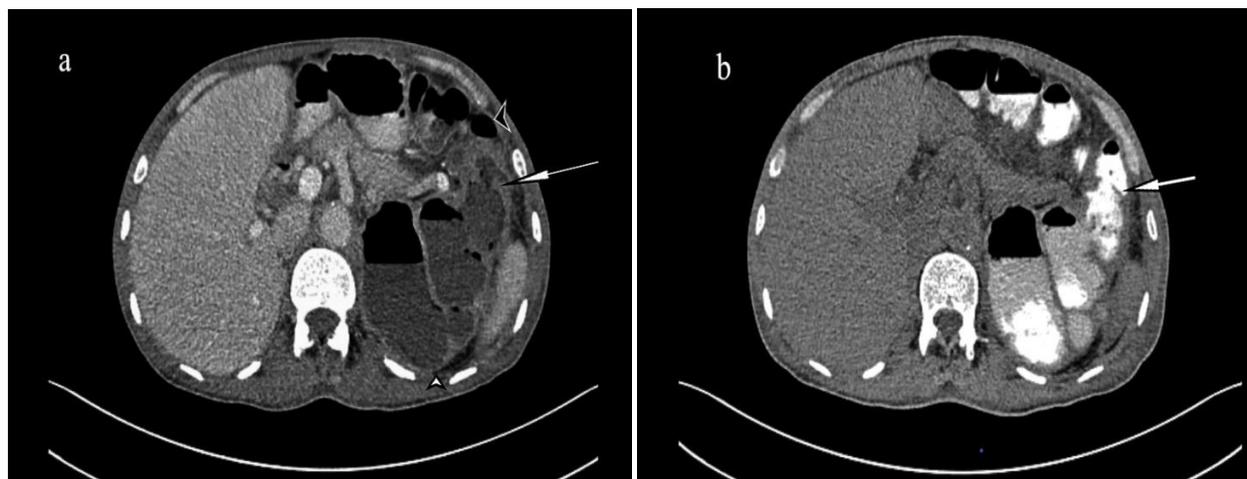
(a) Axial CT image of patient revealed gross hydronephrosis in left kidney (white arrow head) with a fistulous tract (white arrow) and distended bowel loops (black arrow head) (b) Axial CT image of patient with rectal contrast media in left pelvicalyceal system via the fistulous tract at splenic flexure (white arrow)
